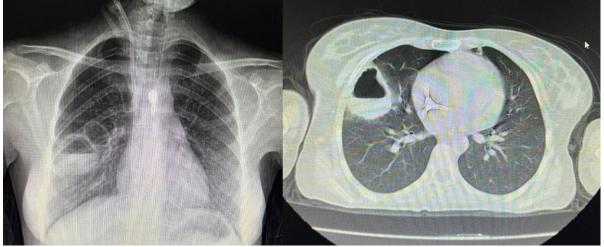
Chest radiograph and axial CT images from the patient demonstrate a large cavity in the right lung containing fluid and air, consistent with a lung abscess.
